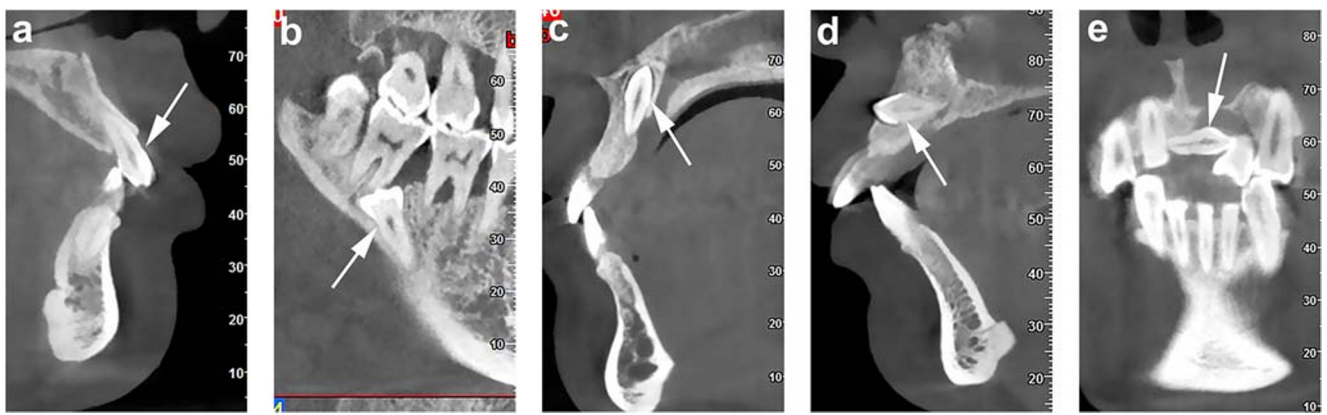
Representative CBCT images exhibiting orientation of ST. a Normal orientation; b inclined orientation; c inverted orientation; d transverse orientation; e horizontal orientation. The white arrows point to the ST in the CBCT images
